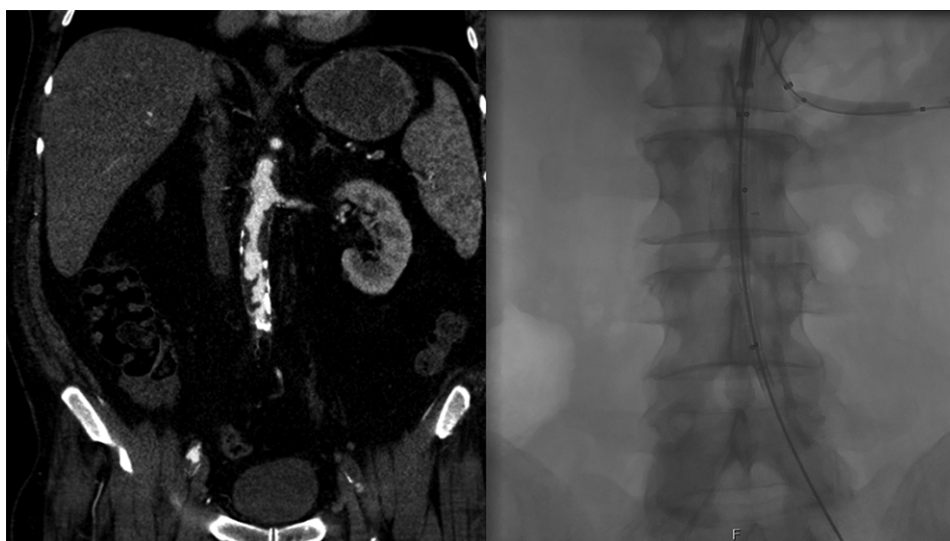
Patient with extensive aorto-iliac occlusive disease. The preoperative CT image in the coronal view shows a shaggy aorta. To protect the left renal artery from embolization while stenting the aorta, a protective balloon was inserted. Unfortunately, the result was massive embolization into the mesenteric arteries and left renal artery as well as the right profunda femoris. The patient survived with ileostomy, colonostomy, and right transfemoral amputation
